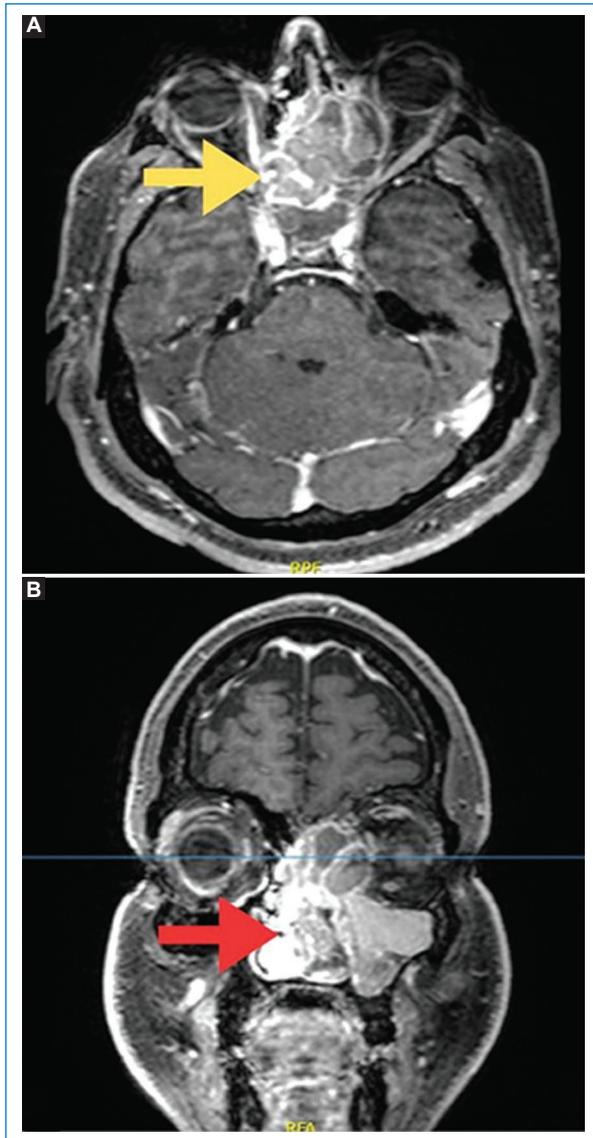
Magnetic resonance imaging of paranasal sinuses with gadolinium contrast, T1-weighted with fat suppression. A: heterogeneous enhancement of the tumor in the left nasal cavity, invasion of the orbit and displacement of the ipsilateral medial rectus muscle and optic nerve (arrow). B: extension to the left maxillary sinus (arrow).
